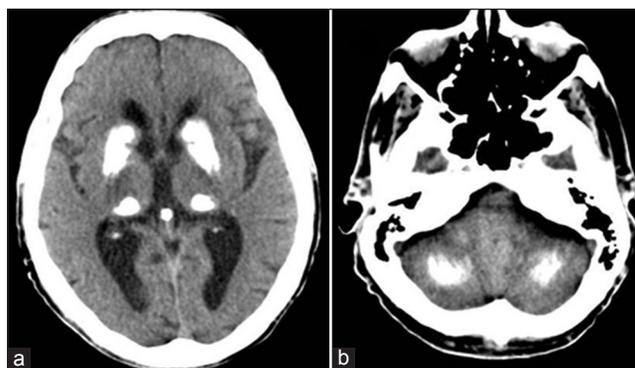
Brain CT scan: Brain non-contrast transaxial CT scan demonstrating dramatic bilateral and symmetric calcifications in caudate nucleus, lentiform nucleus, thalamus (a), and cerebellar dentate nucleus (b)
